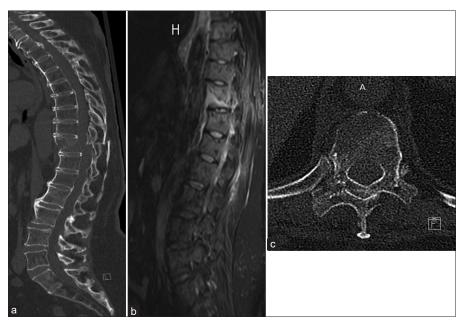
(a) Computed tomography, sagittal view, transverse fracture of T11, subluxation of the vertebral body. (b) T2-weighted magnetic resonance imaging, sagittal view, injury of the posterior ligament complex. (c) Computed axial tomography, axial view, double image of vertebral laminae due to subluxation.
